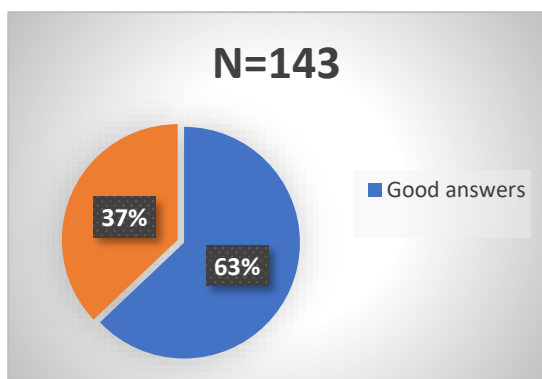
Prescribers' knowledge of medical imaging techniques using X-rays
